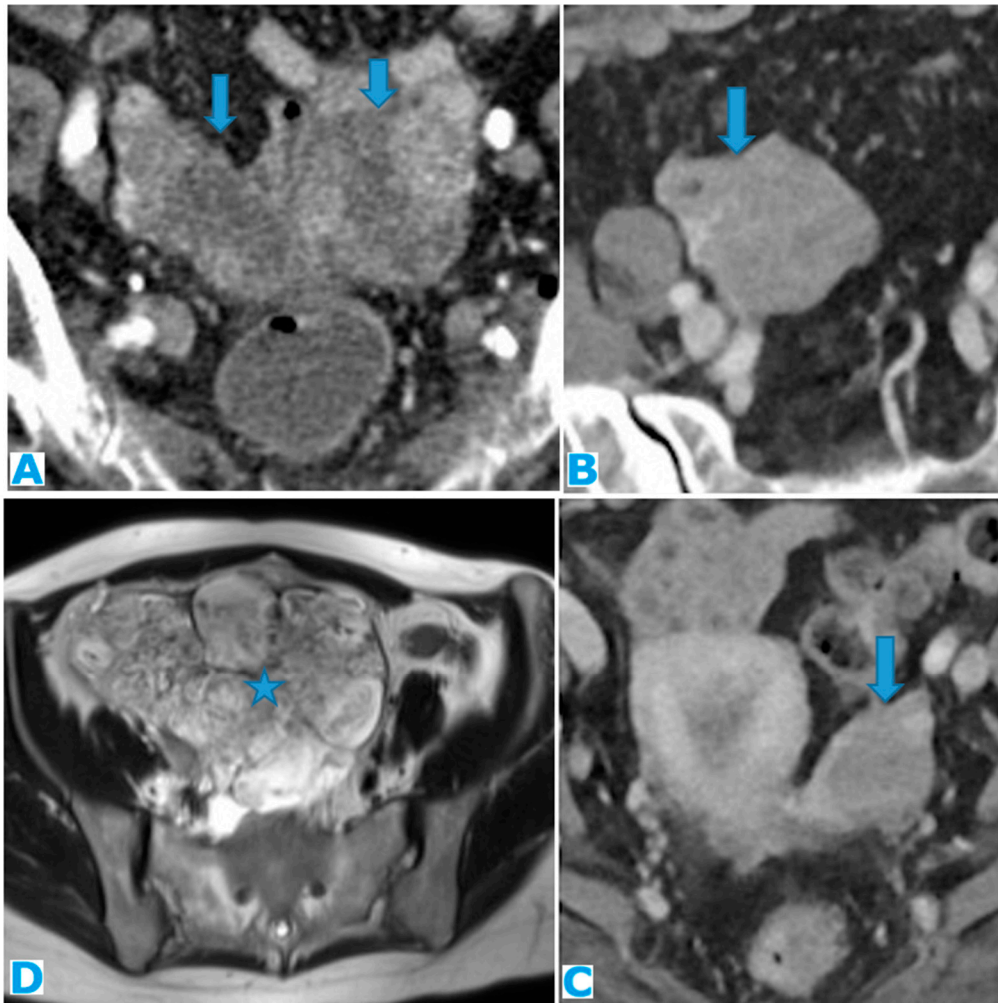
Axial CE-CT (A). PC from sigmoid adenocarcinoma: Bilateral ovarian metastasis as complex cystic masses with solid poles. Axial CE-CT (B, D). PC from colon adenocarcinoma: Bilateral ovarian metastasis as solid masses. Axial T2WI (C). PC from mucinous tumour of the appendix: Left ovarian metastases (*) presenting as a predominantly hyperintense mass due to the mucin content.
